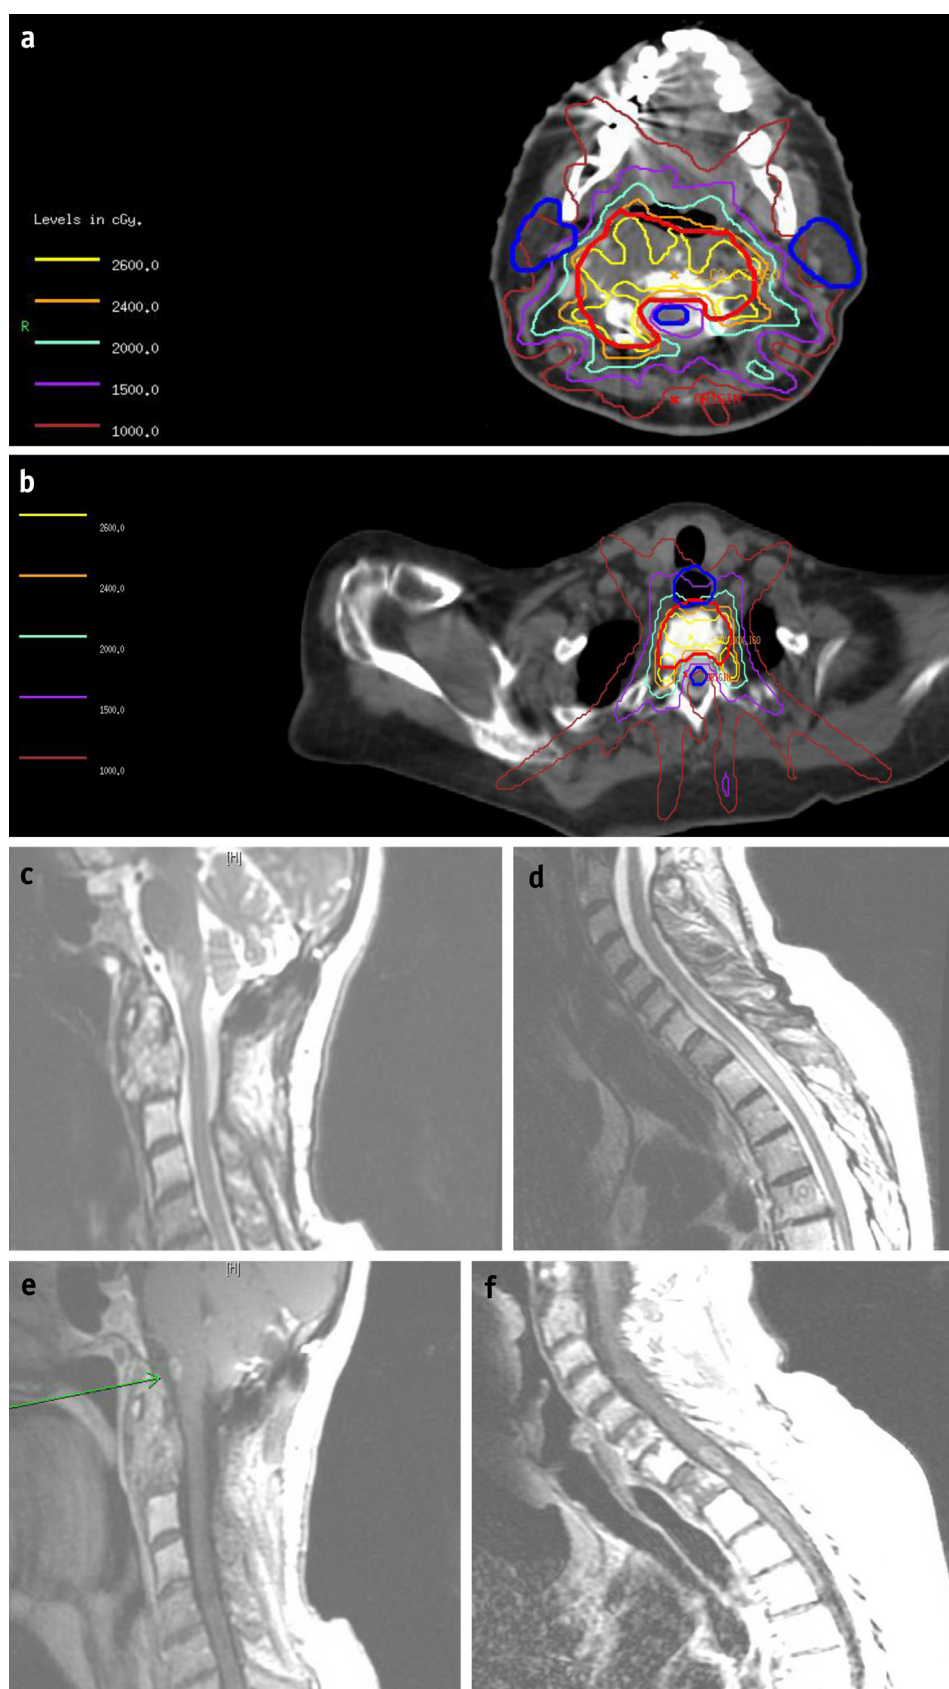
Radiation treatment plans for myelitis cases. (a) Stereotactic radiosurgery (SRS) to C1-C3. (b) SRS to T1. (c, d) Sagittal magnetic resonance image (MRI) of T2 series showing signal intensity in the spinal cord (SC) segments treated. (e, f) Sagittal MRI of T1 postcontrast images showing enhancement in the SC segments treated.
